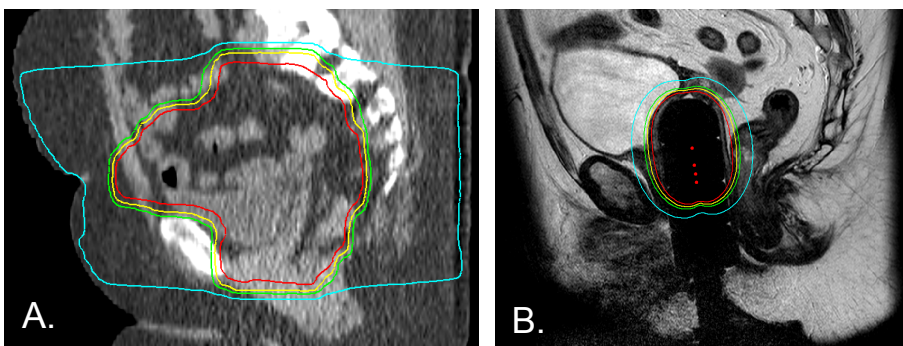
(A) Pelvic external beam radiotherapy dose distribution on CT in the sagittal midplane, in red 95% isodose of 46 Gy. (B) Vaginal brachytherapy using a 3.5 cm vaginal cylinder, dose distribution on MRI in the sagittal midplane, in red 100% isodose of 7 Gy at 0.5 cm distance of the applicator surface.
